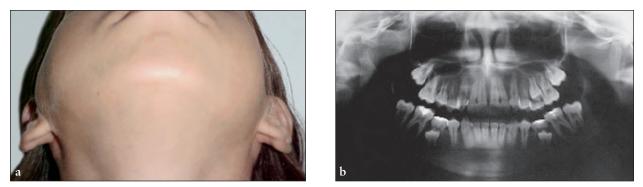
(a) Clinical aspect of facial asymmetry on the right preauricular area; (b) Panoramic radiograph showing the right condylar erosion compared to the left normal joint.
